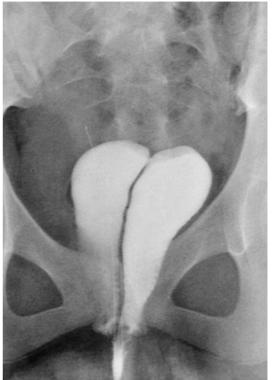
Uterus didelphys with double vagina in a 16-year-old girl. a Filling of the vagina with plain sodium solution. Transverse sonogram shows two uteri (*closed arrowheads*) with thickened, echogenic endometrium (*asterisks*) and two fluid-filled vaginas (*V*) behind the empty bladder. b With a slightly oblique transducer position no sonographic dropout occurs and allows clear demonstration of the two separate vaginas (*V*). *B*, Bladder. c Contrast filling of the vagina. Anterior posterior view of the double vagina after retrograde filling. The septum is clearly visible
